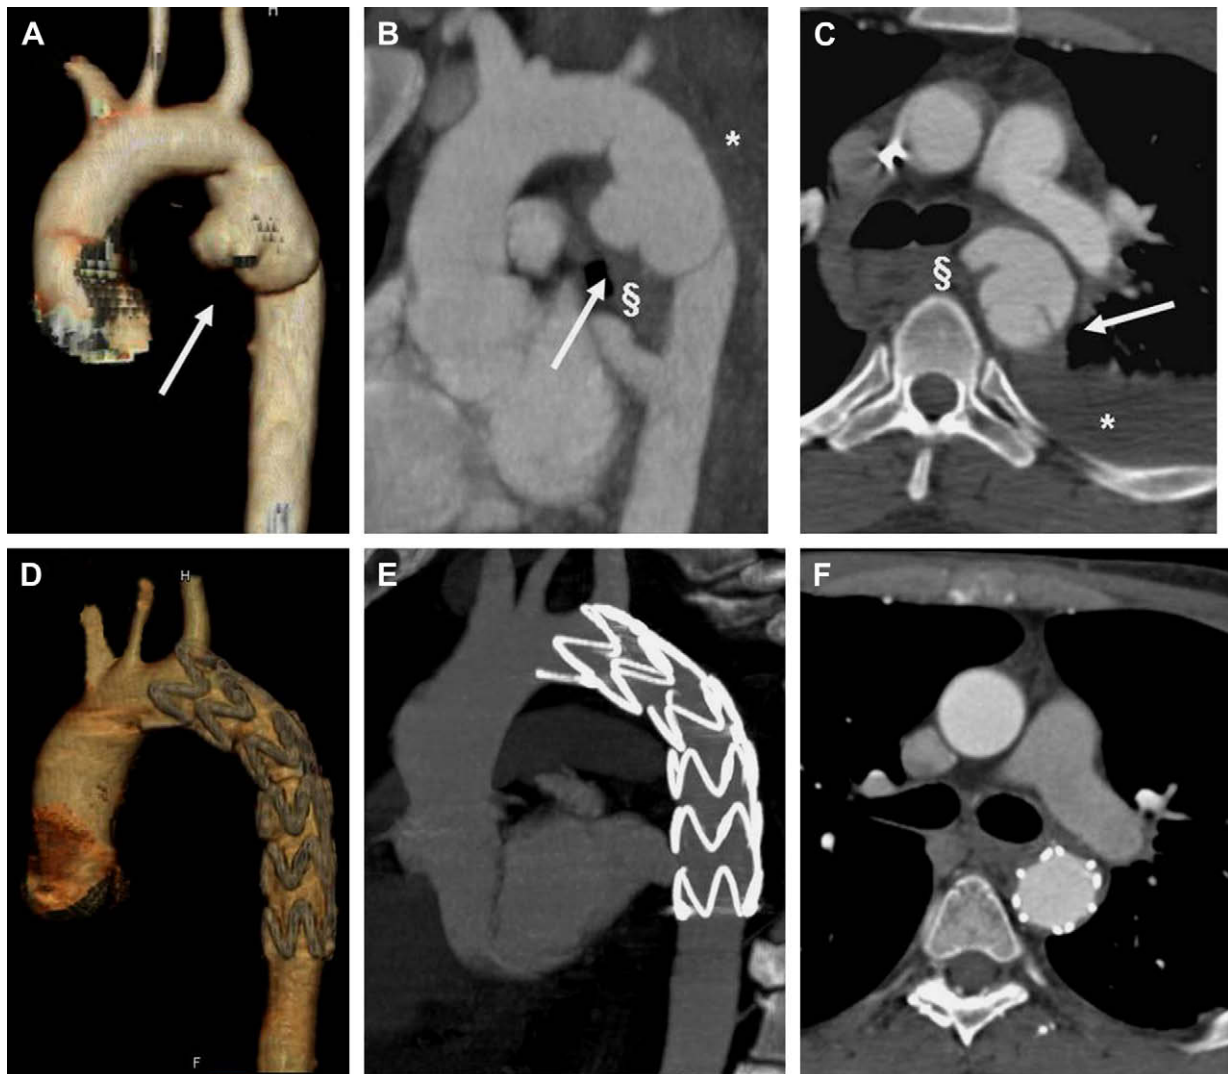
Multidetector CT images of an acute traumatic aortic injury before (A–C) and after (D–F) endovascular treatment: a circumferential aortic injury could be easily detected (arrows), together with periaortic mediastinal hematoma (§) and pleural effusion (*). The lesion is very close to the left subclavian artery. After endovascular treatment, the lesion is completely resolved as well as pleural effusion and mediastinic hematoma. The left subclavian artery is open.
